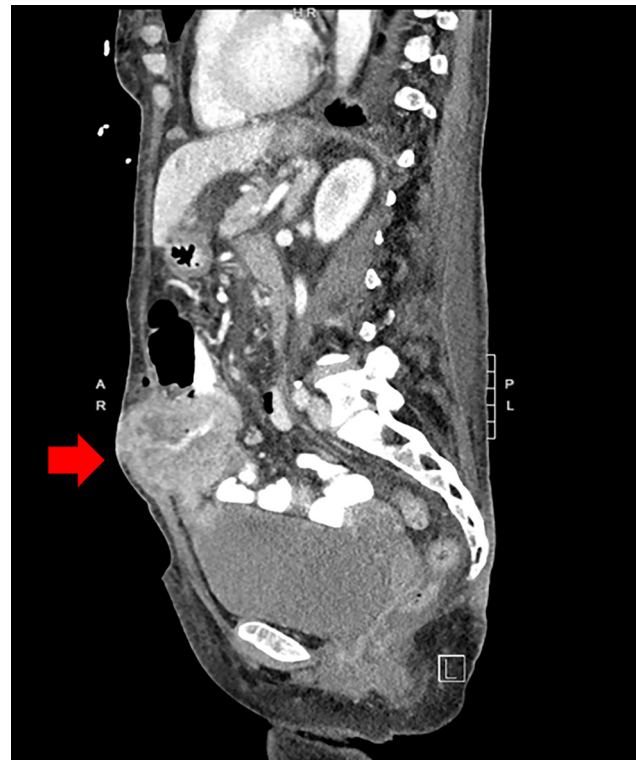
CT of the abdomen and pelvis with IV and oral contrast; sagittal view. Red arrow: 8 cm abdominal mass involving the bladder, transverse colon, and small bowel.
